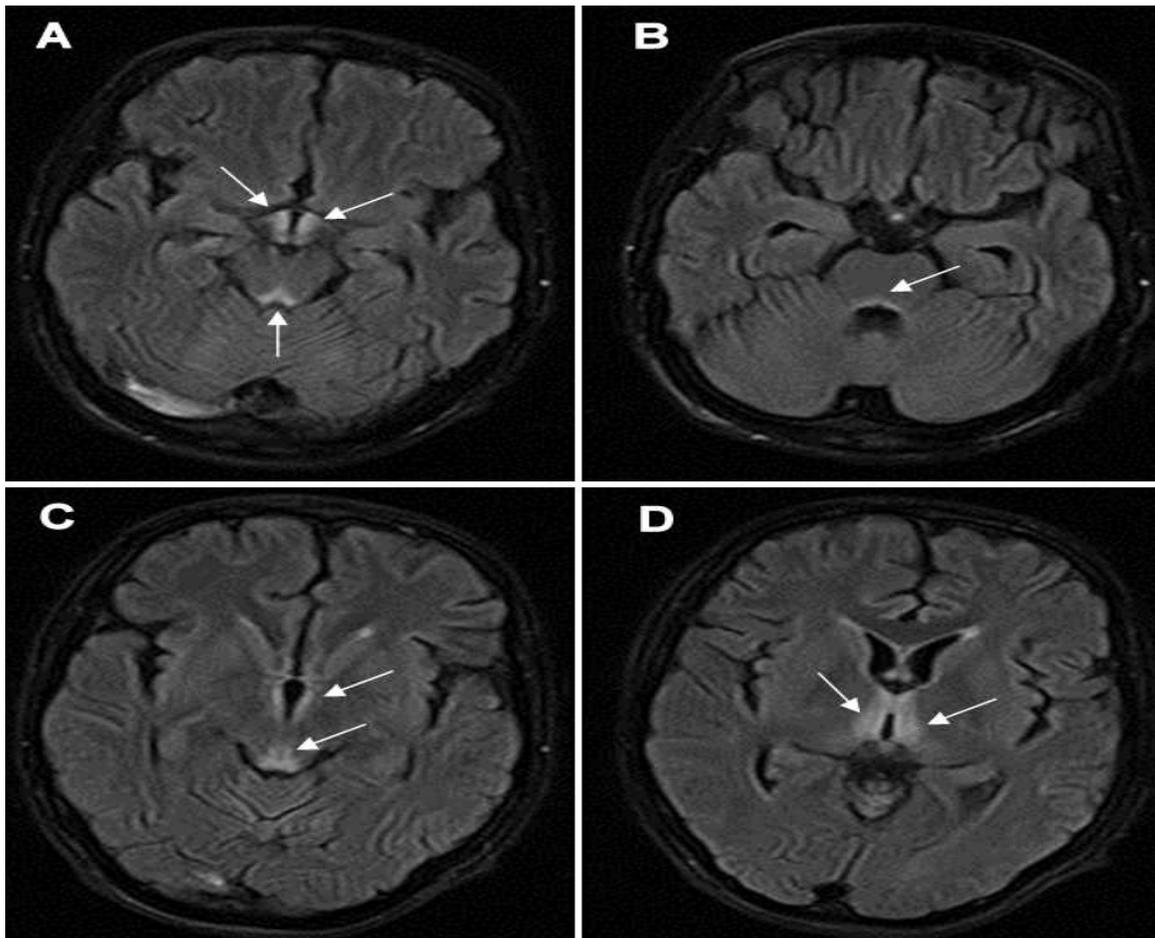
Brain MRI on FLAIR in a nonalcoholic young man with WE due to malnutrition. Hypersignal lesions are observed in; A: tectalplate and mammillary bodies; B,C: periventricular regions; and D: medial thalamus
